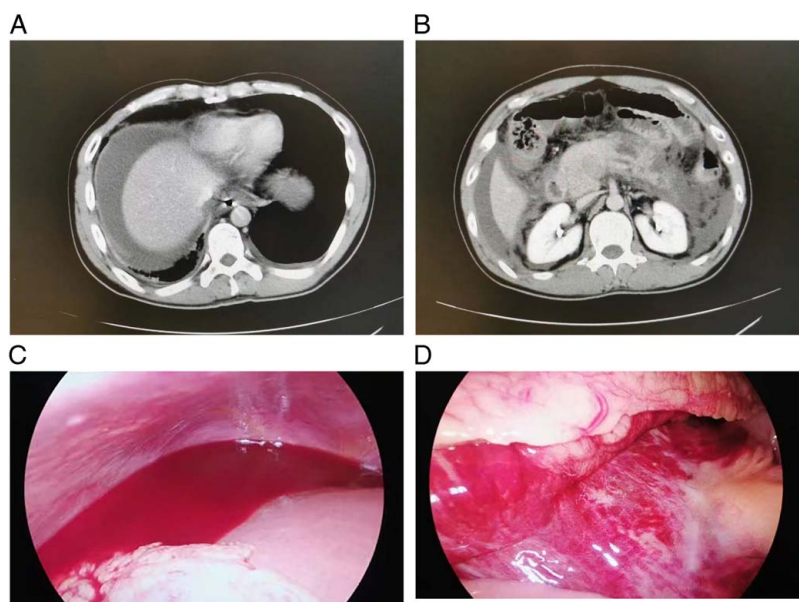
A 33-year-old male with acute hemorrhagic necrotizing pancreatitis complicated by multiple organ dysfunction and hyperkalemia. Perihepatic effusion was observed on CT imaging (A). CT revealed pancreatic swelling and necrosis of the body and tail (B). Laparoscopic exploration identified a significant amount of bloody effusion surrounding the liver (C). Laparoscopic exploration detected retroperitoneal swelling and hematoma (D).
